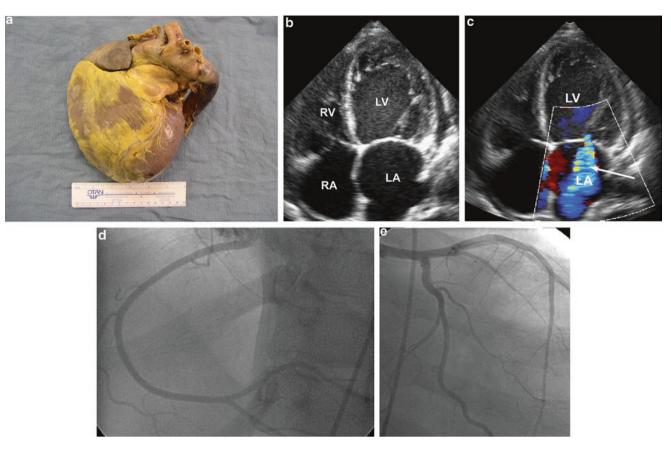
(a) Dilated cardiomyopathy with marked four-chamber enlargement and globular shape of the heart. (b) Dilated cardiomyopathy. Echocardiogram. Apical four-chamber view. Diffuse dilatation left ventricle (LV), left atrium (LA), and right atrium (RA). (c) Color Doppler from (b) demonstrates moderate to severe mitral regurgitation (arrow). (d) Normal left coronary arteriogram from patient in (b). (e) Right coronary arteriograms from same patient in (b); normal features are present
